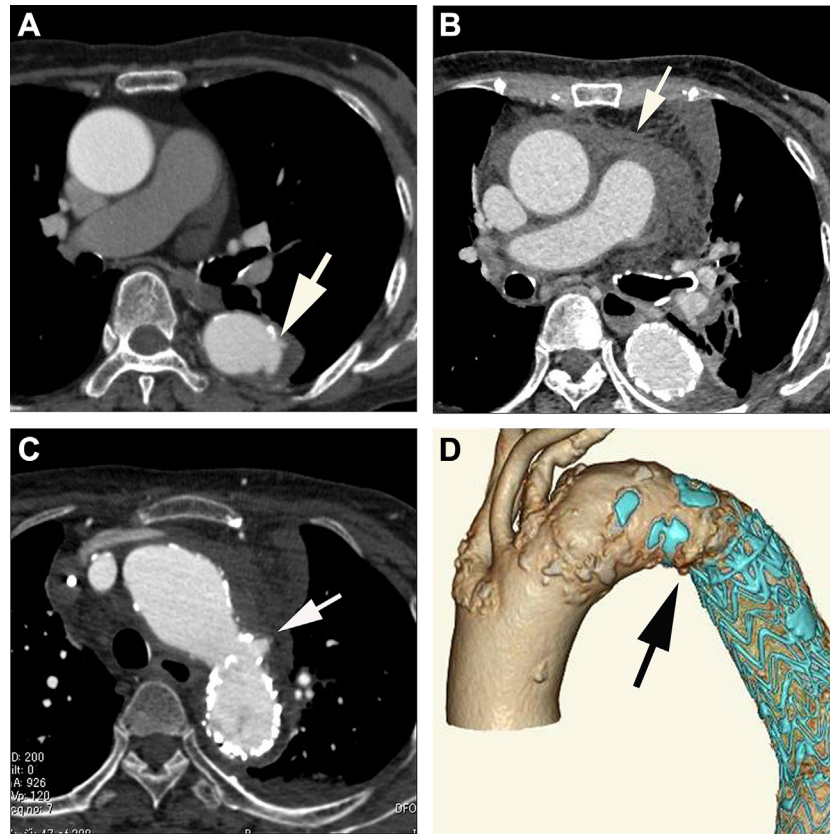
An 83-year-old woman with type B acute intramural hematoma (IMH) of the aorta. A, A contrast-enhanced computed tomography (CT) image 3 months after onset shows progressive ulcer-like projection (ULP) in the descending aorta (*arrow*). B, She had severe chest pain 1 year after endovascular treatment. A contrast-enhanced CT image shows that ULP had disappeared; however, mediastinal hematoma is seen (*arrow*). C, Contrast-enhanced CT images show a pseudoaneurysm caused by the edge of the stent graft in the aortic arch (*arrow*). D, CT angiography shows pseudoaneurysm caused by the edge of the stent graft in the aortic arch (*arrow*).
